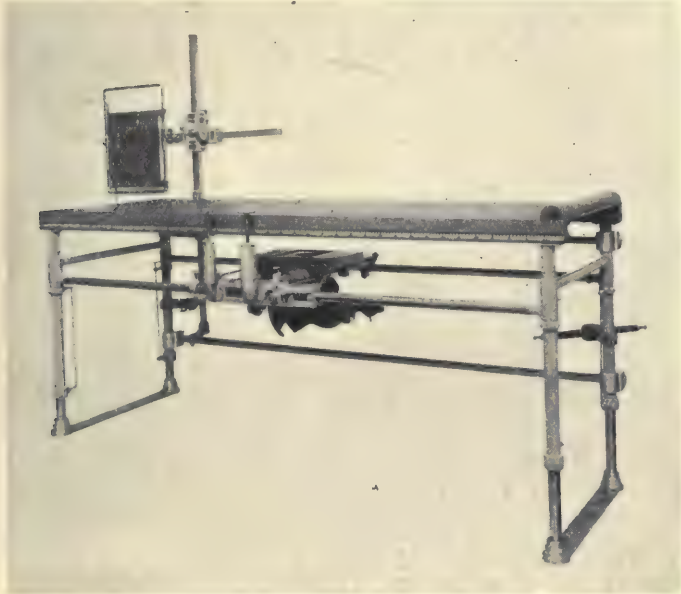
X-ray surgical table by Dr. Ledoux-Lebard (Gallot & Co.). Its frame is made entirely of metal and consequently very solid and perfectly rigid, whatever the height or the inclination adopted. The carrier is designed from the universal X-ray table by Dr. J. Belot and has all its advantages and is as easily worked. We see in this figure and in the preceding one the bathymeter by Dr. Dessane supported by a sliding arm which can also be used as a stand for the tube carrier and can be raised if required. In this sketch the legs have been purposely raised unequally at the ends.
